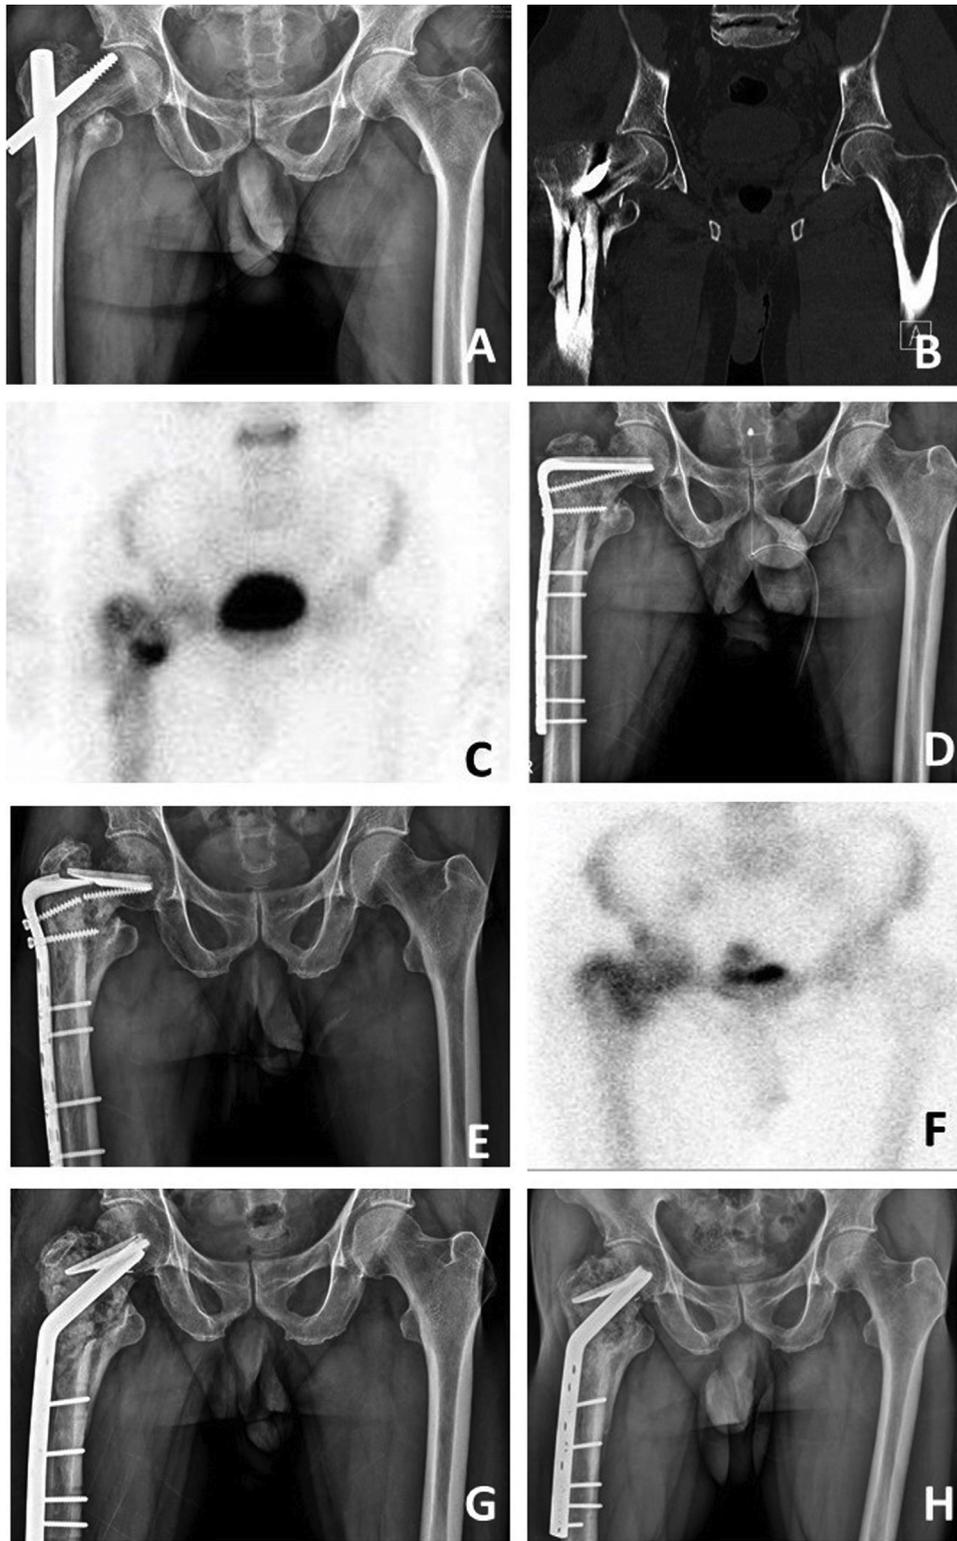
A 67-year-old man underwent valgus intertrochanteric osteotomy because of fixation failure of intertrochanteric fracture. (A) Radiograph obtained 3 months after fixation shows fixation failure with a cut-off of the cephalomedullary screw. (B) Computed tomography image shows destruction of the superior portion of the femoral head with non-union of intertrochanteric fracture. (C) Bone scintigraphy image shows viability of femoral head. (D) Radiograph obtained 2 weeks after re-fixation with 95° angled blade plate shows under-correction of the neck-shaft angle. (E) Radiograph obtained 10 months after re-fixation shows fixation failure with non-union. (F) Bone scintigraphy image shows viability of the femoral head. (G) Radiograph obtained 4 weeks after valgus intertrochanteric osteotomy shows restoration of the neck-shaft angle. (H) Radiograph obtained 15 months after osteotomy shows union at the osteotomy site.
